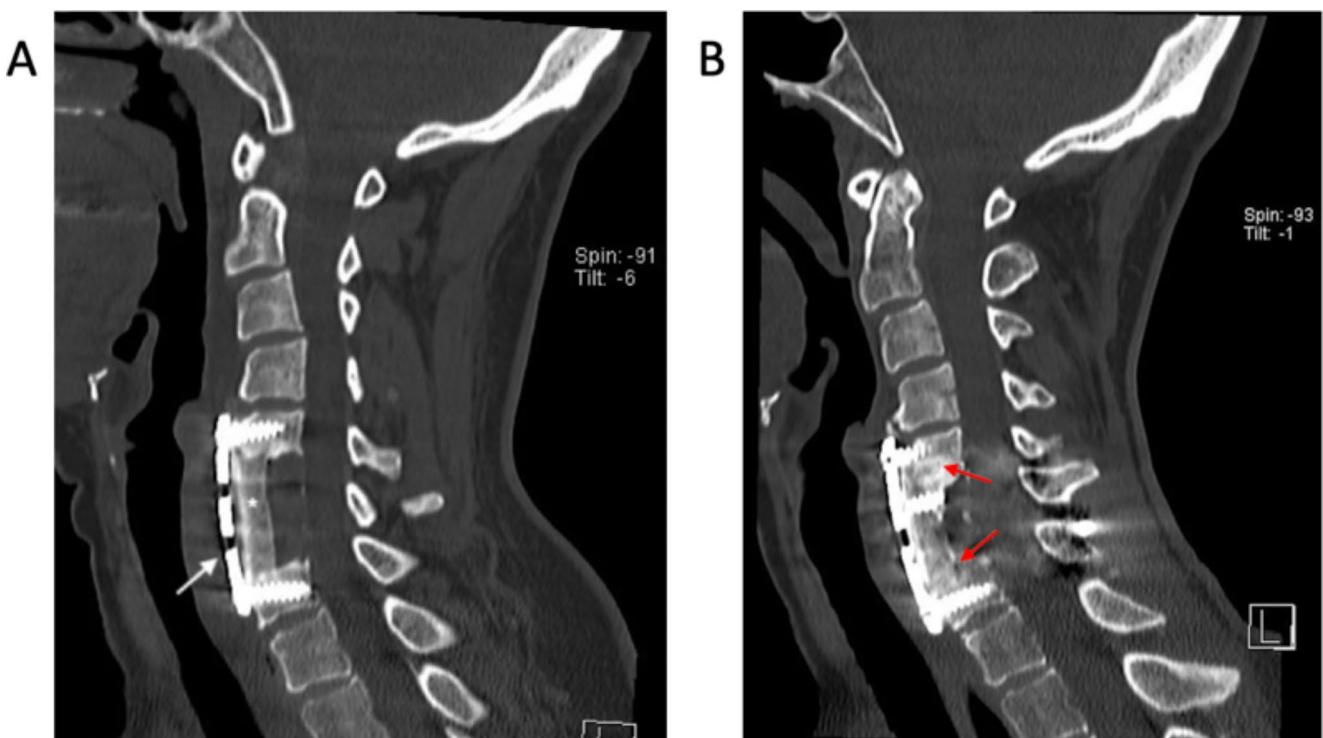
CT images of the patient taken at the time of admission to our hospital (left) and the most recent preoperative scan (right), showing initial areas of osteolysis (red arrows) and their progression (white arrows)
